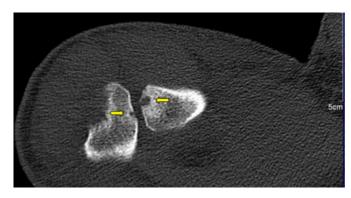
Figure 2: Retrospective review of the right shoulder CT confirmed small focal marginal erosions in the articular cortex of the right ACJ.
